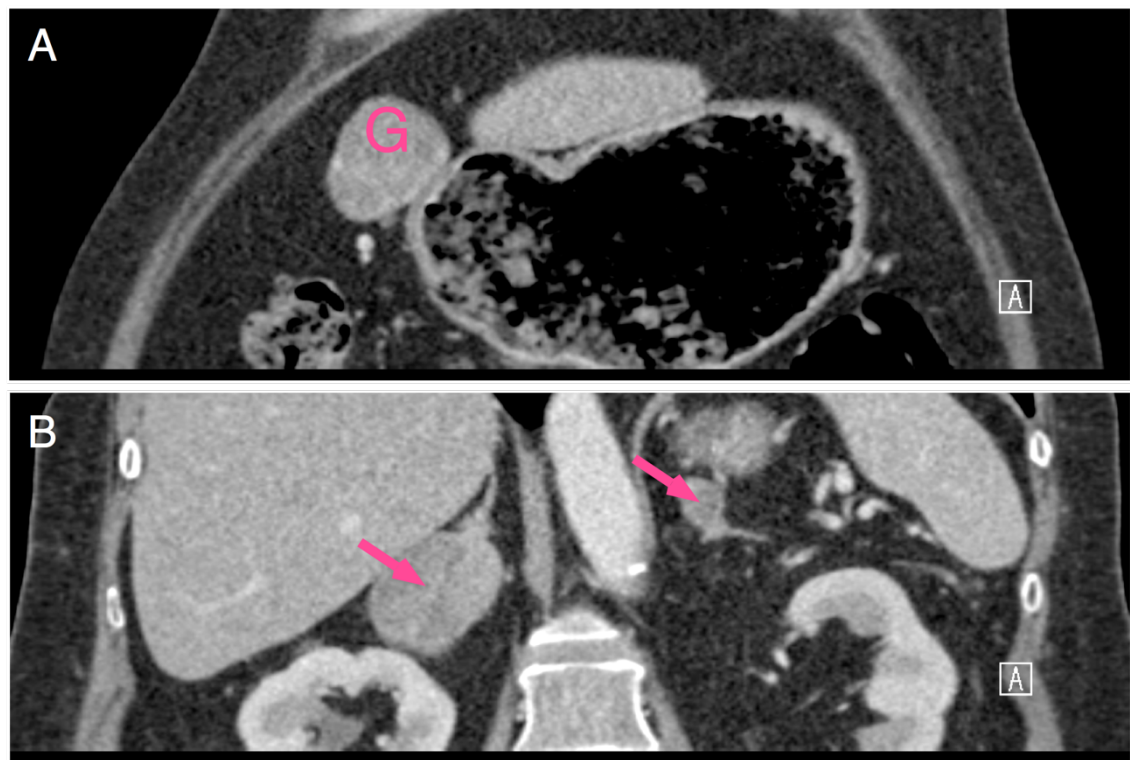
Non-contrast CT scan of the abdomen
